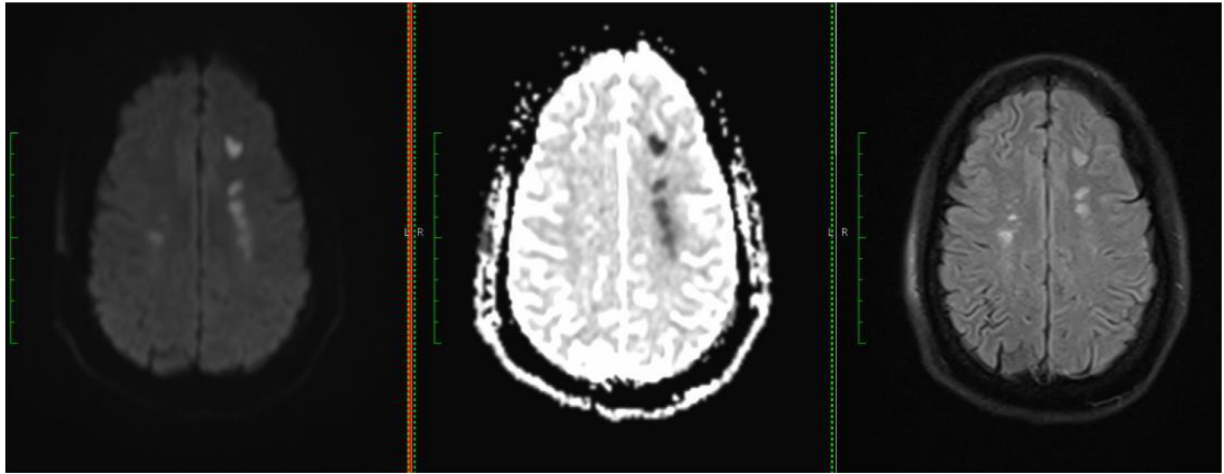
MRI DWI, ADC, FLAIR images showing acute watershed territory infarcts in left centrum semiovale and subacute infarct in right centrum semiovale.
